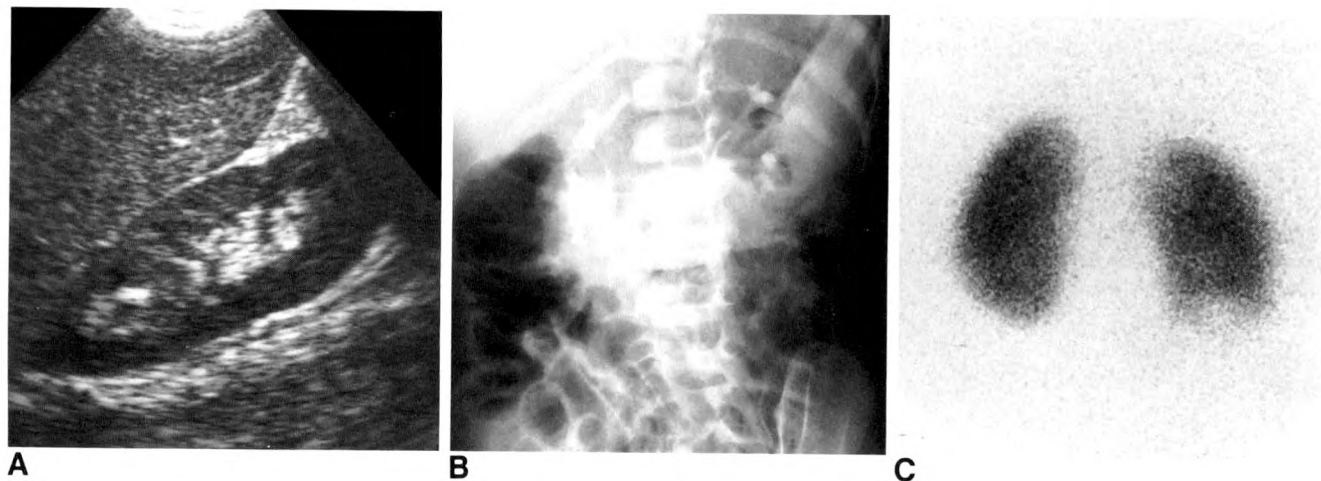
A, Longitudinal sonogram of right kidney of a 4-year-old girl with suspected urinary tract infection shows a duplex collecting system but is otherwise normal.
